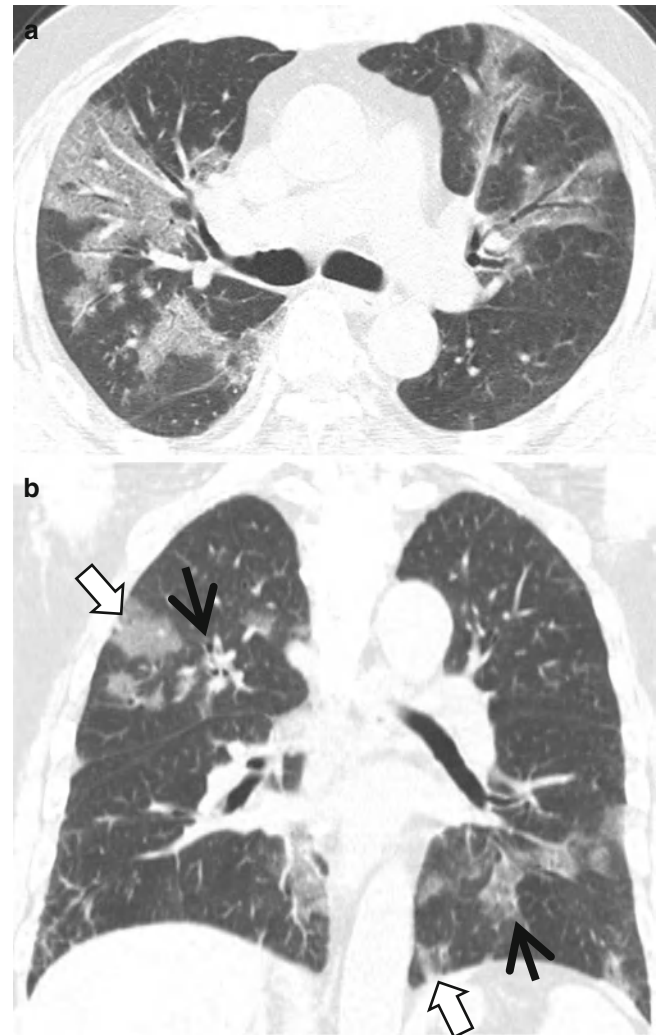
Influenza A (H1N1) pneumonia showing cryptogenic organizing pneumonia pattern in a 66-year-old man. (a) Lung window image of CT scan (2.5-mm section thickness) obtained at level of right upper lobar bronchus shows patchy areas of ground-glass opacity distributed mainly along bronchovascular bundles in both lungs. (b) Coronal reformatted (2.0-mm section thickness) CT scan also demonstrates parenchymal opacity lesions distributed along bronchovascular bundles (arrows) or subpleural (open arrows) lungs (Reprinted from Kang et al. [8] with permission)
